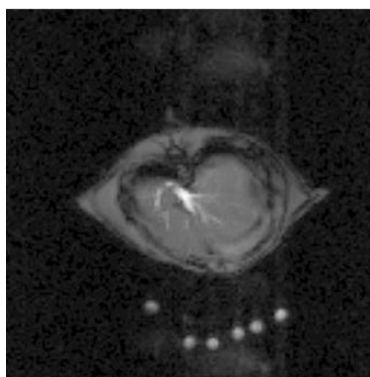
Representative axial 1H-MRI of woodchuck with HCC
